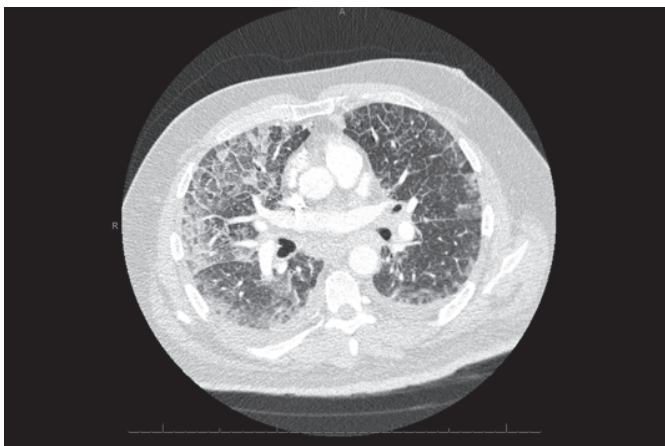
Chest computed tomography scan demonstrating diffuse bilateral ground-glass opacities, interlobular septal thickening, and “crazy-paving” pattern.
